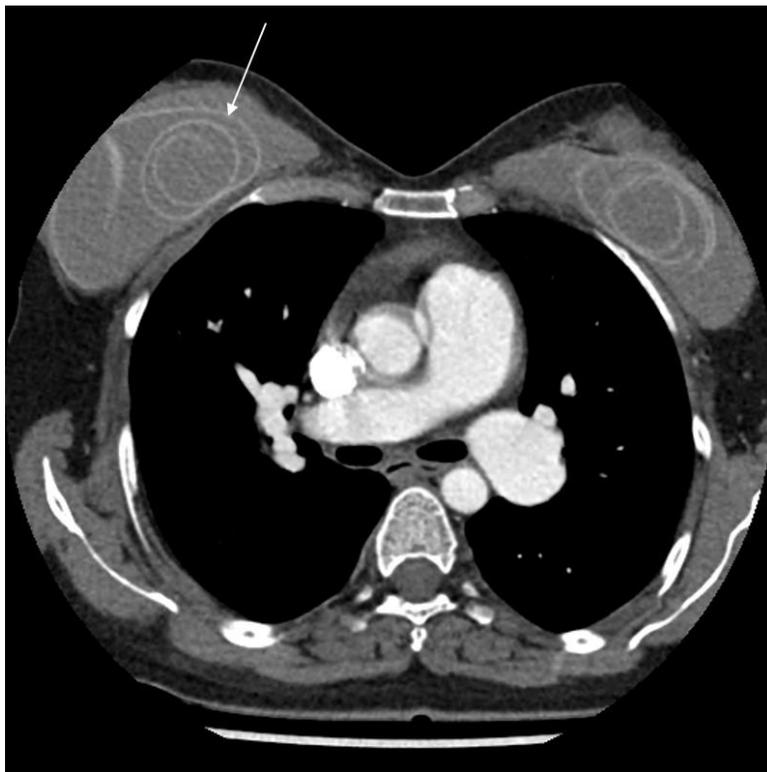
Chest CT demonstrating intracapsular rupture of both breast implants, multiple linear structures parallel to the implant capsule (arrow), consistent with the ‘linguine sign’, while the implant contents remain contained within the surrounding fibrous capsule without extracapsular leakage
